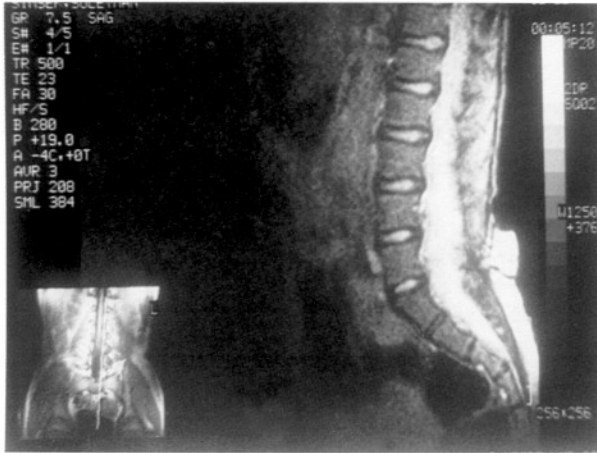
The MRI view of the case: The cyst and tethered cord are seen in the lumbar region in flash sequences series.
